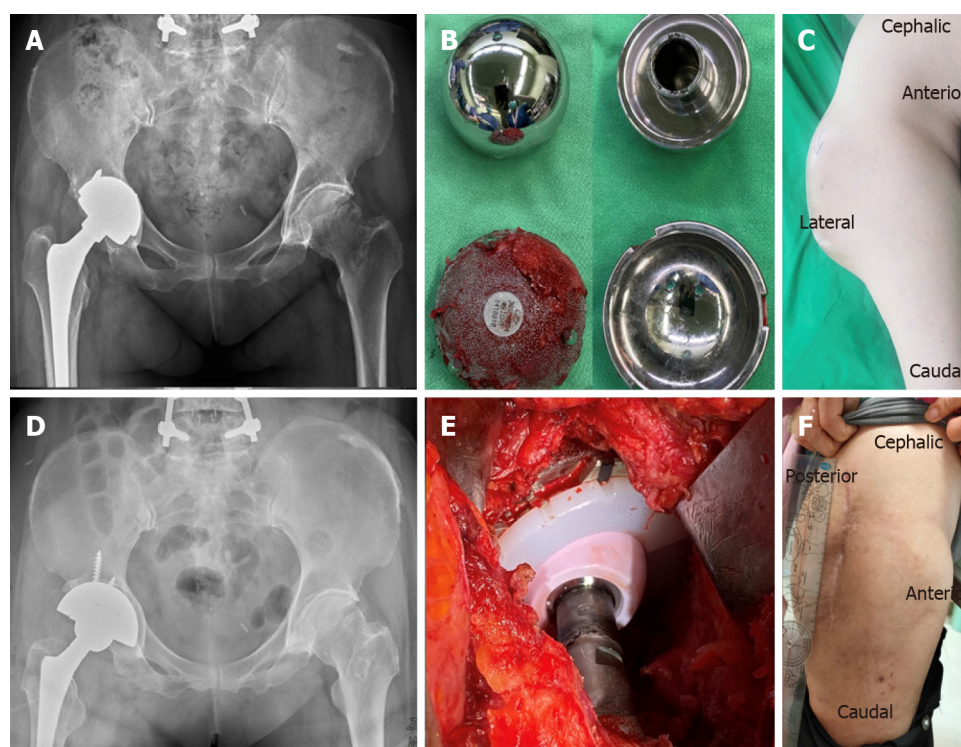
Pre-operative and post-operative series images. A: Radiography of metal-on-metal total hip arthroplasty (THA) over right hip; B: The metal-on-metal acetabular cup and femoral head removed from revision surgery. Surface scratching and erosion was observed between the cup/head component; C: Pre-operative gross photo (AP view) of right hip showed mass protruding at lateral side of right hip; D and E: Radiography and gross photo of revision ceramic-on-polyethylene THA; F: Post-revision gross photo (lateral view) of patient after locally tigecycline injection showed subsidence of the mass at 24-mo follow-up.
